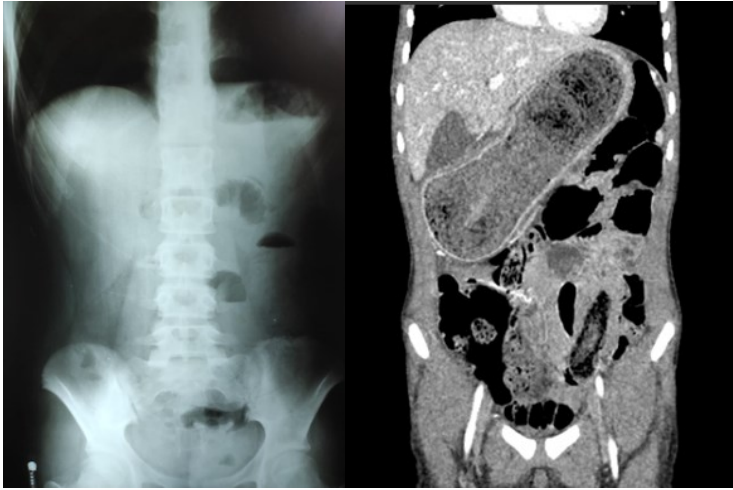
Contrast-enhanced abdominal CT scan showing gastric distension and endoluminal content. Gastric distension is an enlargement of the stomach that can be caused by various conditions such as intestinal obstruction, stomach ulcers, or stomach cancer. Endoluminal content refers to material present within the lumen of the stomach or intestines.
